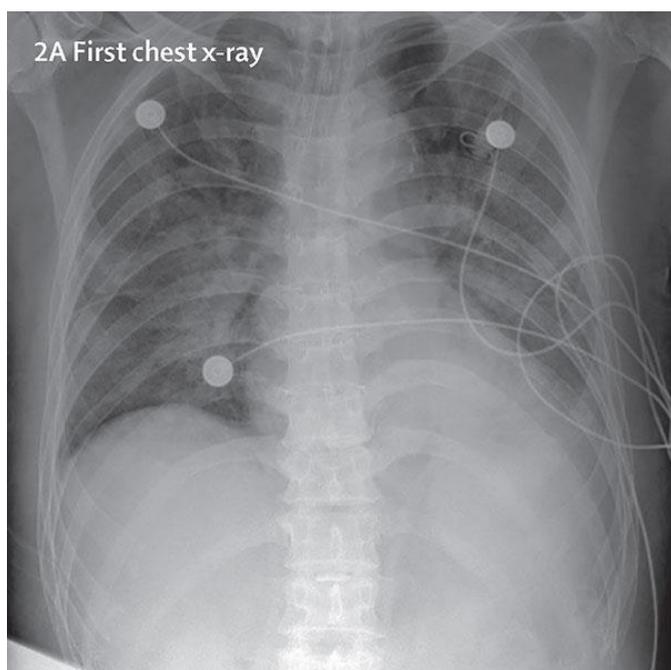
COVID19 Positive Patient Chest X-Ray
